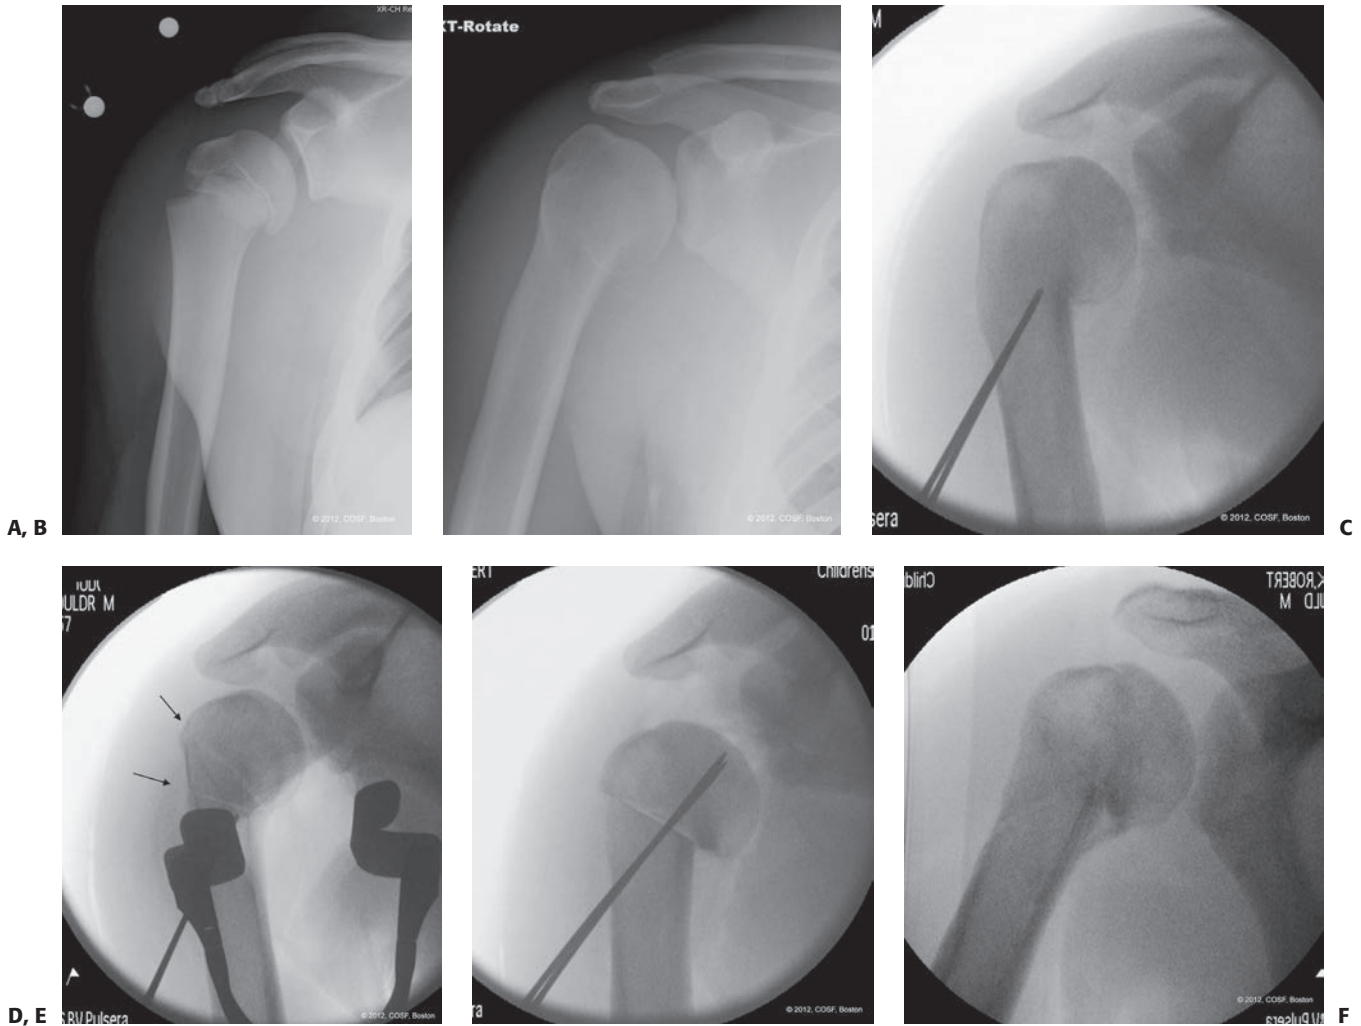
A: AP radiograph of a minimally displaced right proximal humeral physeal fracture in a 14-year-old male. B: Follow-up radiographs depicting humerus varus, characterized by a decreased neck-shaft angle and high-riding greater tuberosity resulting in limited shoulder abduction and bony impingement. C: Intraoperative image during corrective osteotomy, depicting percutaneous pin placement. D: Converging osteotomies (*arrows*) are made to create a lateral closing wedge osteotomy. E: Osteotomy fixed using percutaneous pins and a tension-band fixation construction. F: Follow-up radiographs demonstrating bony healing and restoration of more normal proximal humeral alignment.
